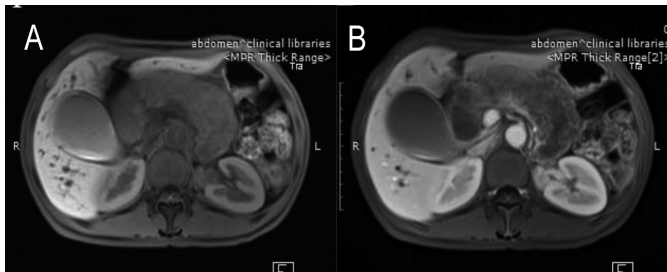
(A, B) MRI showed diffuse enlargement of the pancreas, which showed a change in homogeneity after angiography.
